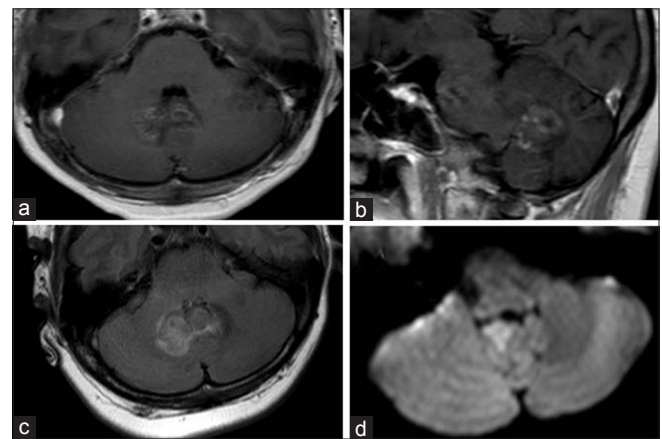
(a and b) T1-enhanced axial, sagittal magnetic resonance image showing infratentorial lesion affecting deep structures, including the cerebellar vermis. The lesion is juxtaventricular (fourth ventricle), but not cause obstructive hydrocephalus. (c) Fluid-attenuated inversion recovery demonstrated brain edema around the lesion. (d) Diffusion-weighted image showing a restricted diffusion lesion of abscess
